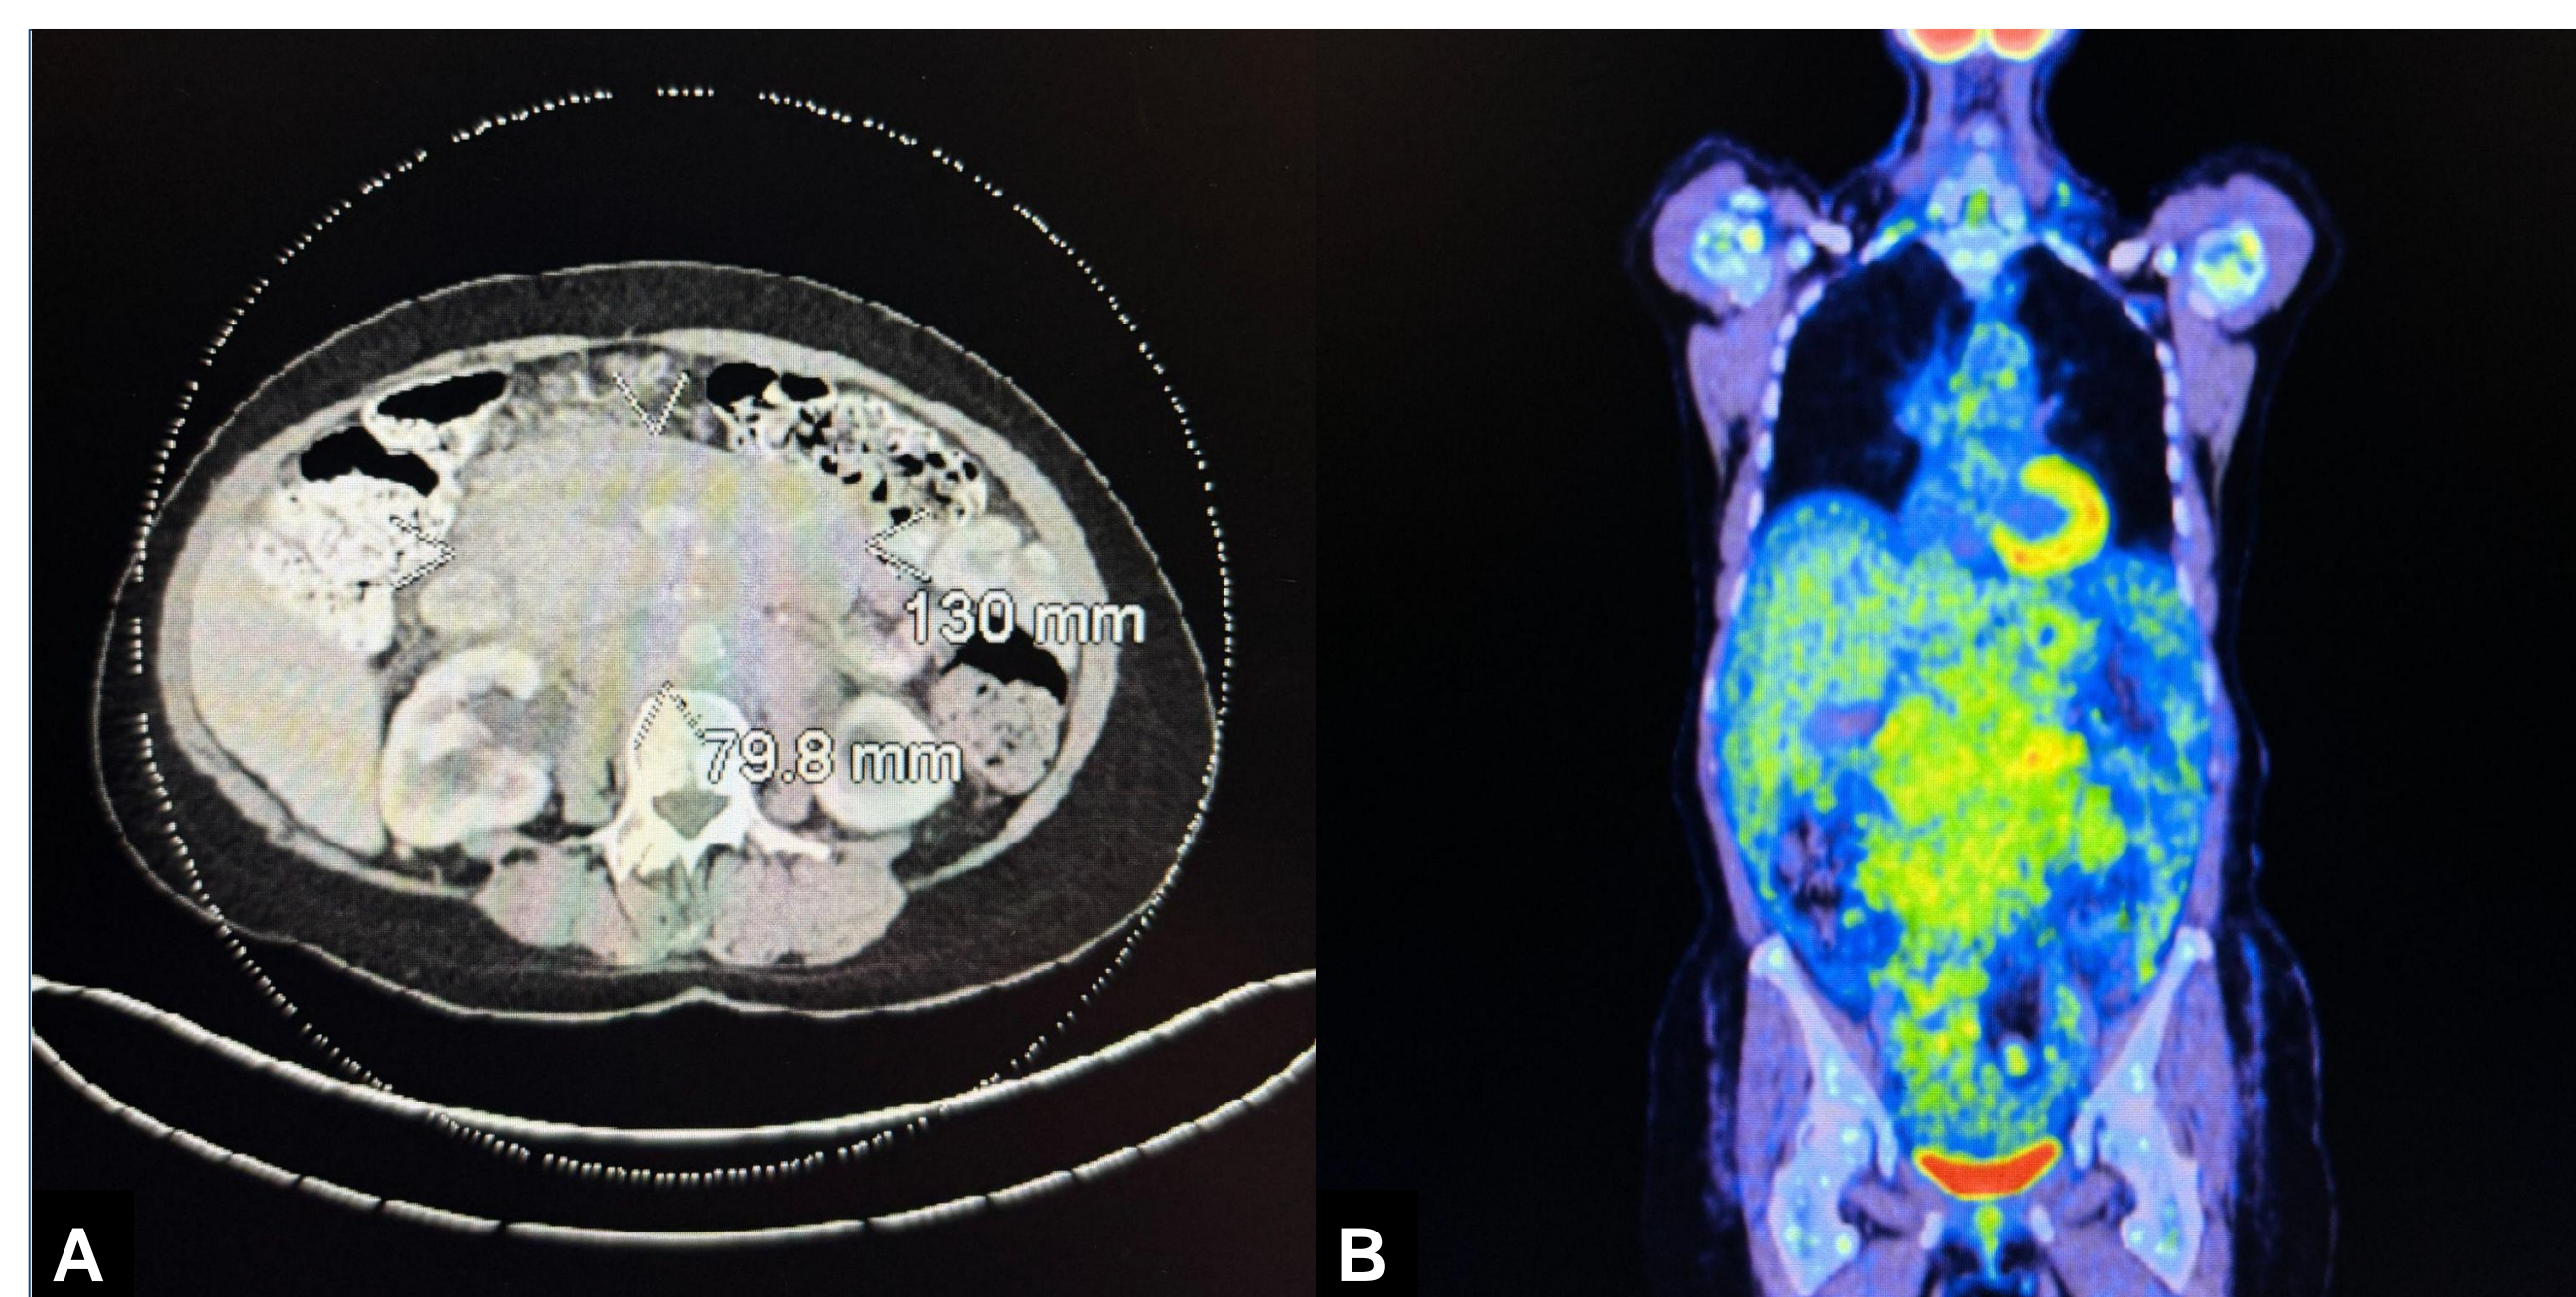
Follicular lymphoma. (A) CT imaging demonstrated a large (8 x 13 cm) retroperitoneal mass. (B) PET imaging revealed FDG avid abdominal adenopathy.
